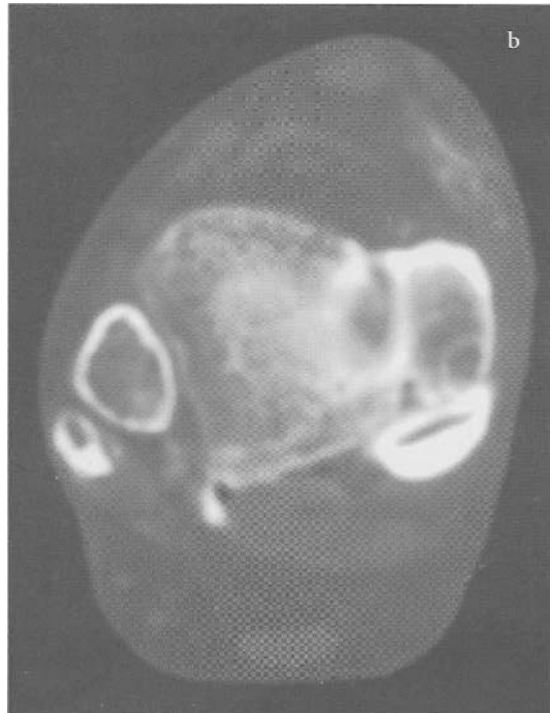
CT: soft tissue window. Sinus tarsi pannus on the left side (arrow).
